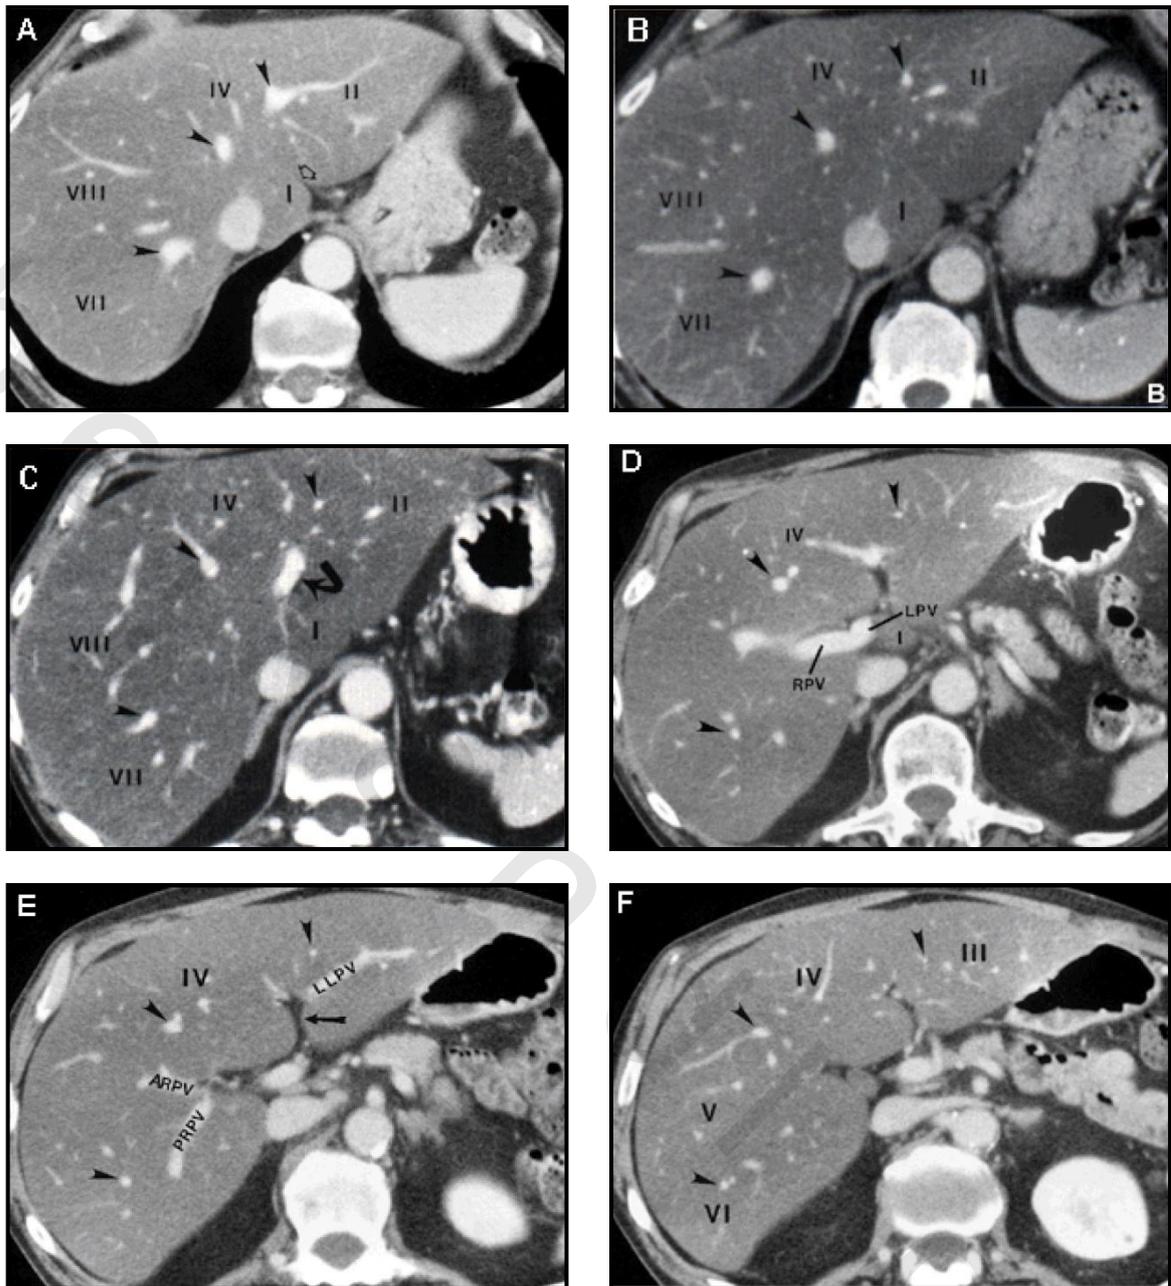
Hepatic cross-sectional anatomy by CT⁽¹¹⁾.
